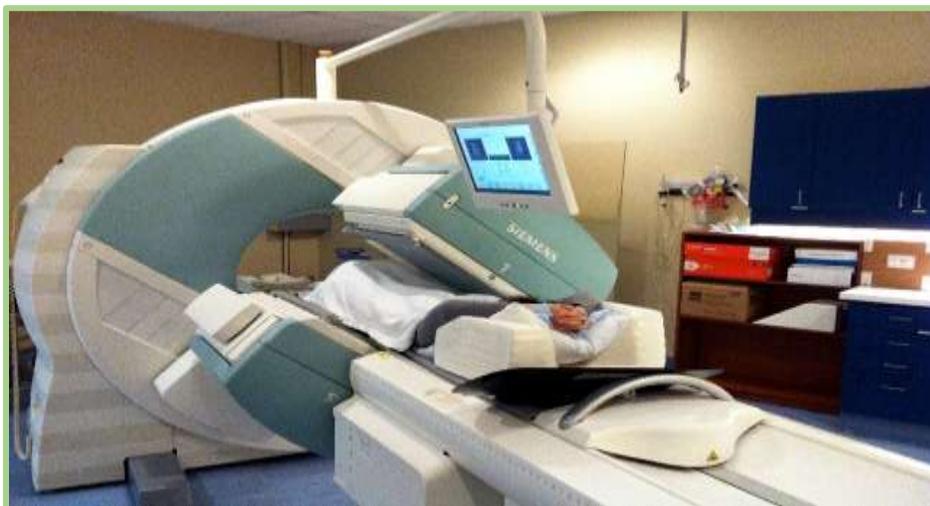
Siemens SPECT machine performing a total body bone scan at the Credit Valley Hospital. Source: Yrottier (2012). CC BY-SA 3.0. File: SPECT CT. JPG.
